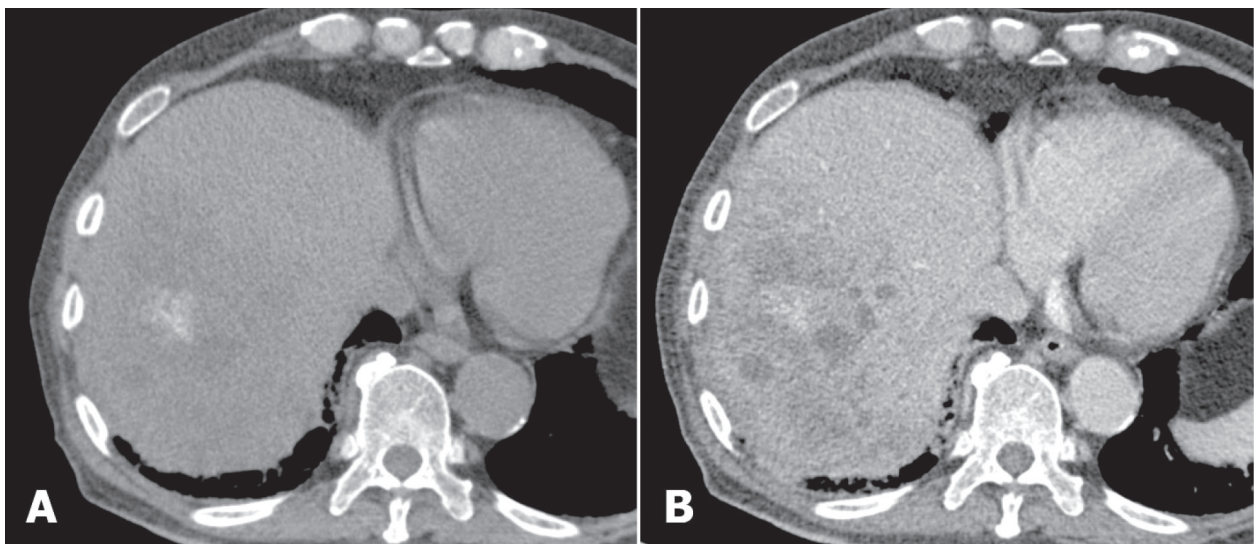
Various CT appearances of non-mucinous CA.
